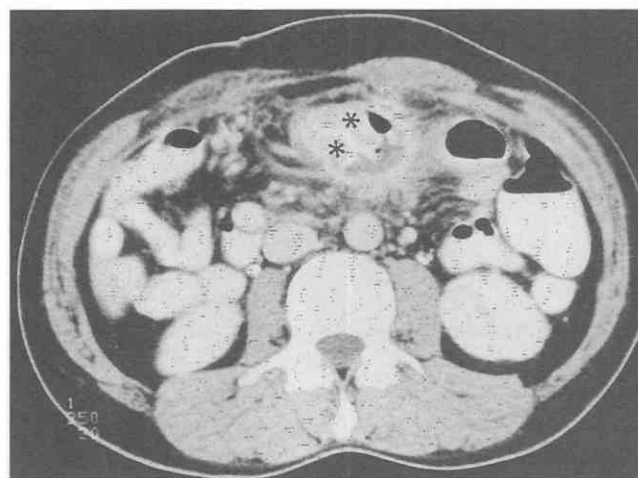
Recurrent Behçet's syndrome at the surgical anastomosis. CT scan shows concentric bowel wall thickening (asterisks) at the anastomotic site after right hemicolectomy. Perienteric infiltration and regional mesenteric vascular engorgement are also noted. (From Chung SY, Ha HK, Kim JH, et al: Radiological findings of Behçet's syndrome involving the gastrointestinal tract. *Radiographics* 21:911-924, 2001.)
